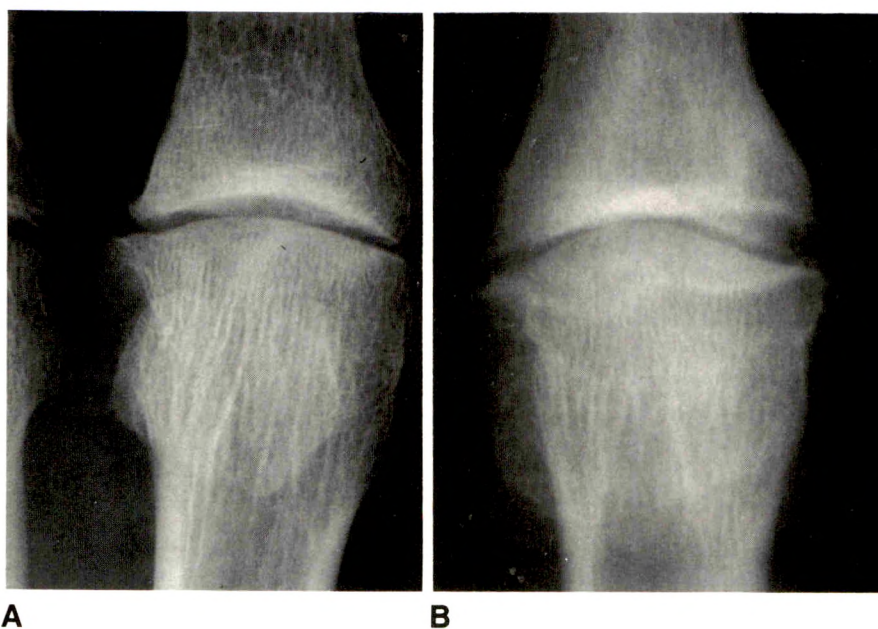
A and B, Moderate hallux rigidus (grade 2). Anteroposterior radiographs of two examples show progressive joint-space narrowing, marginal spurs, and subchondral sclerosis and/or cyst formation.
